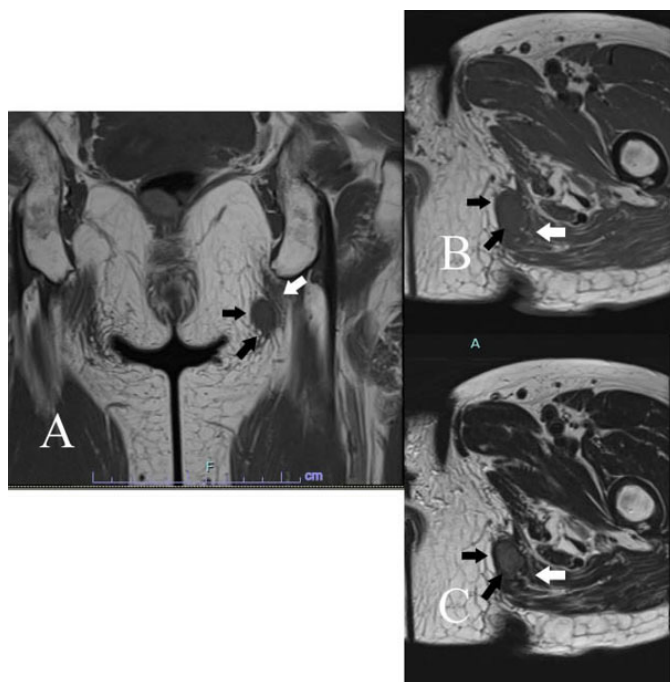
Case 3. Angiofibroma of soft tissue in the buttock coronal (A) and axial (B) MRI shows a mass in the subcutis of buttock (black arrows) and attached to the gluteal fascia (white arrow) that had homogeneous intermediate intensity on T1-weighted image (TR/TE=476/9.90). Corresponding axial T2-weighted image (TR/TE=3110/105) reveals a mass to be inhomogeneously high signal intensity (C).
